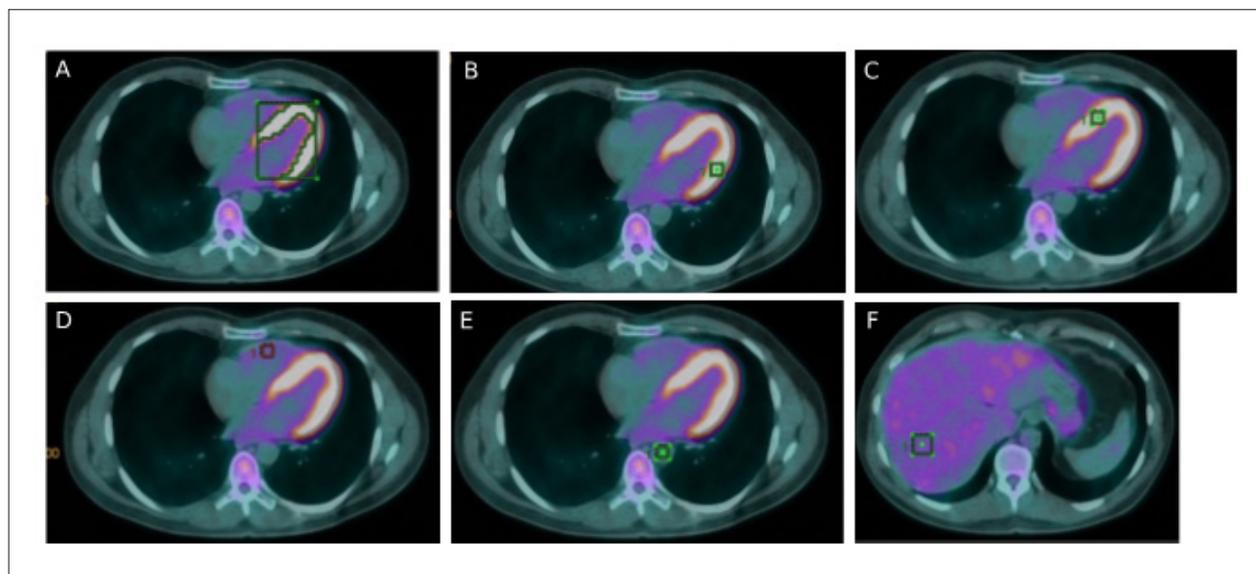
Regions of interest (ROIs) for SUV acquisition in various cardiac sites and in control regions (aorta and liver) (A), global heart SUV; (B), LV free wall SUV; (C), IVS SUV; (D), RV free wall; (E), Aorta SUV; (F), Liver SUV. SUV: standardized uptake value, LV: left ventricle, IVS: interventricular septum, RV: right ventricle
